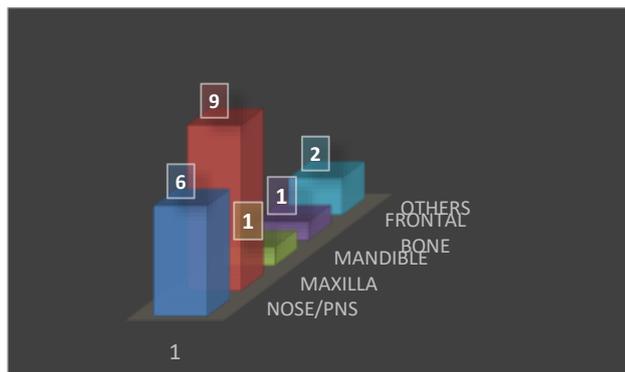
Extend of disease in CBCT.
